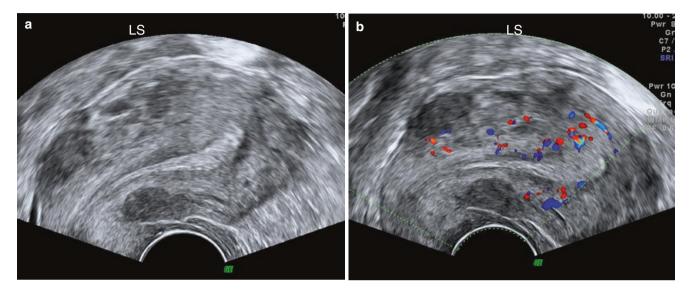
Diffuse uterine leiomyomatosis. LS of uterus on (a) greyscale and (b) Doppler, showing multiple hypoechoic, poorly defined, irregular areas, giving the uterus a heterogeneous appearance. The margins of most of the fibroids are difficult to delineate
